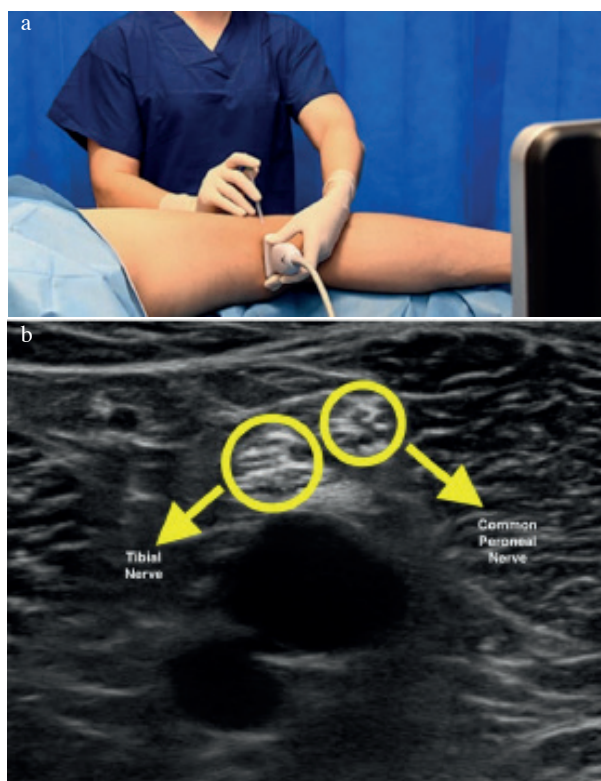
a.* Application of ultrasound guided PFNB technique. *b.* Tibial and common peroneal nerve in popliteal fossa on ultrasound image.
